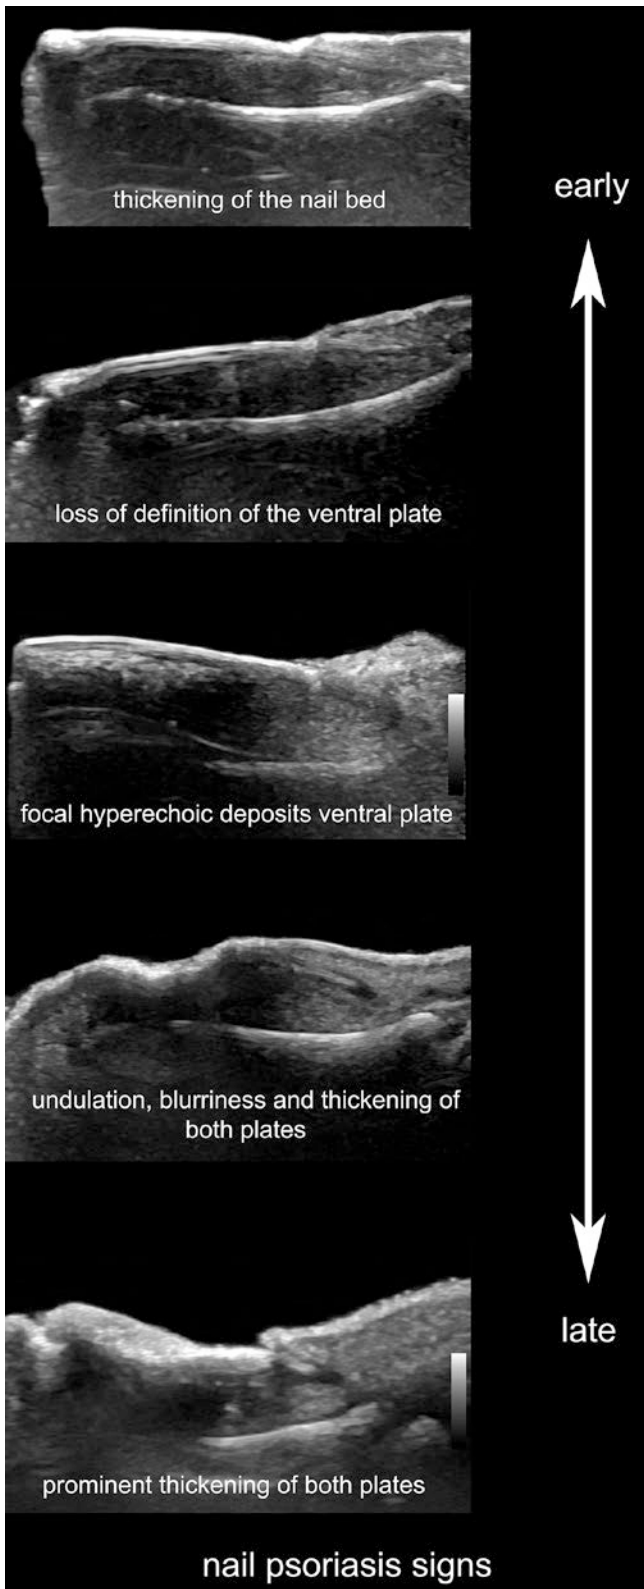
Ultrasonographic signs of nail psoriasis.
